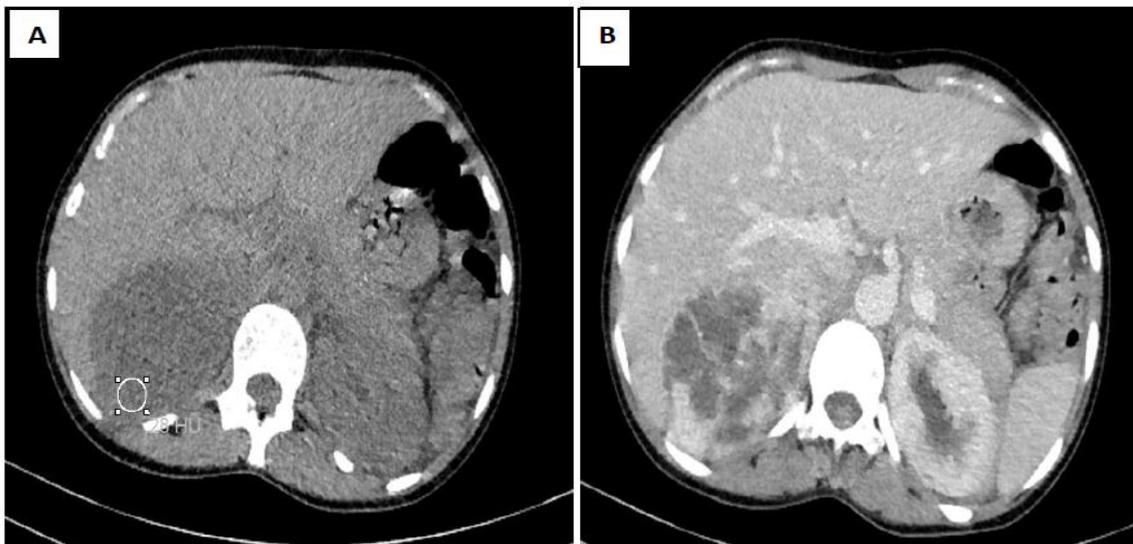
Axial section of an abdominal CT scan showing a right adrenal mass, oval, well circumscribed, heterogeneous with areas of necrosis without calcifications, coming into contact with the liver anteriorly and the diaphragmatic pillar posteriorly (A), enhanced early and heterogeneously after injection (B).
